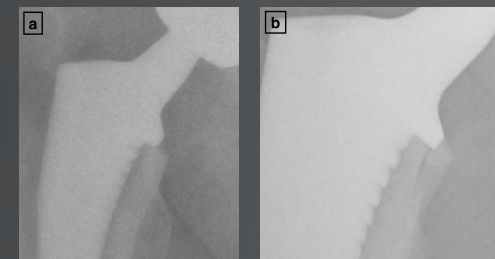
(a) Primary dual-taper THA patient with initial collar-calcus contact shown on intraoperative x-ray vs (b) 3 mm stem subsidence and a nondisplaced calcar fracture at 4 weeks postoperatively. Two patients (0.4%) in the dual-taper cohort had these early postoperative calcar fractures, both of which healed uneventfully.
